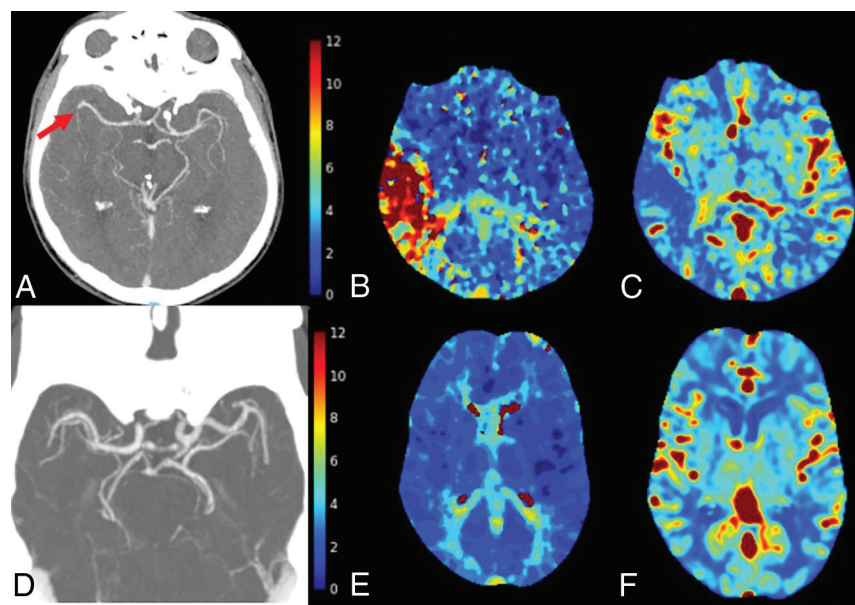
Examples of 20-mL CTA performed on small-detector-width CT (Discovery 750; GE Healthcare). *A*, Axial CTA MIP demonstrates occlusion of the inferior M2 division of the right MCA (arrow) in a 75-year-old man with sudden-onset abnormal left-sided movements. *B* and *C*, A single section of Tmax and rCBF maps shows territorial Tmax delay and a small area of severely reduced relative CBF. *D*, Sample of an axial CTA MIP in a different patient, a 71-year-old woman with right-sided weakness. The patient had a low weight (50 kg), accounting for the superior arterial opacification with the same contrast load. *E* and *F*, Selected Tmax and relative CBF images show that the CTP quality is excellent.
